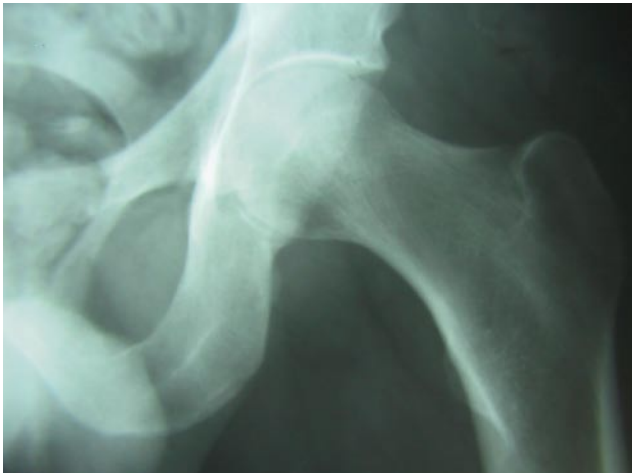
Case 1—Anteroposterior x-ray of left hip reveals osteopenia of femoral head and neck.
